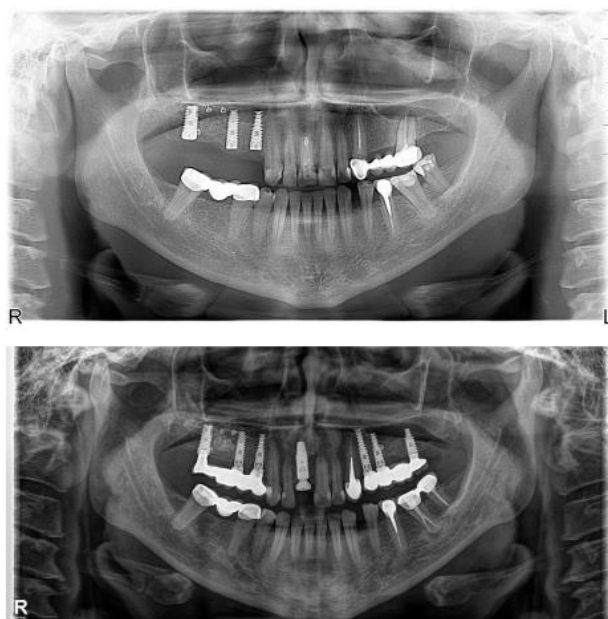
Immediate postoperative view (2015) and follow-up radiograph (2024) demonstrating stable augmented bone volume.
